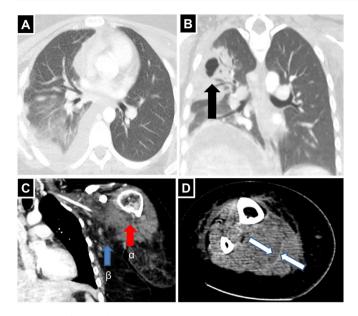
(A and B) A cavitating pneumonia and parapneumonic effusion on admission chest CT. (C) A reactive fluid collection under the oedematous left deltoid muscle, indicating muscle inflammation (α) and extensive fat stranding and inflammation (β). (D) A collection of reactive fluid in-between the superficial and deep fascial planes of the right leg.
